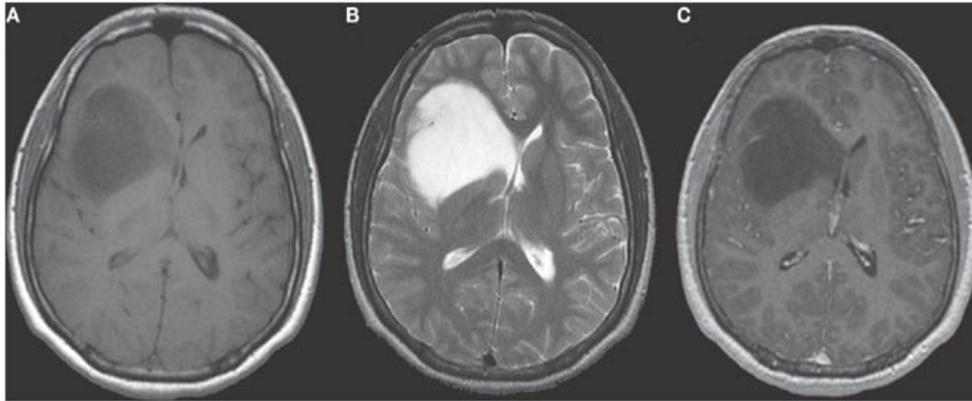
Typical MRI scan of a low-grade glioma [4]
